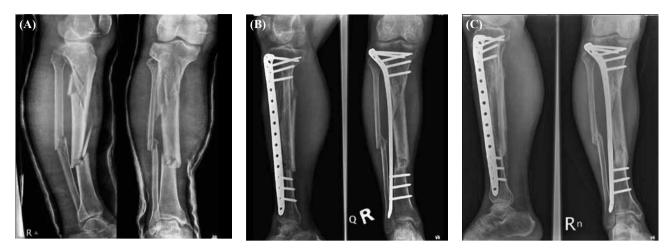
A 48 years old male, suffered from a road traffic accident, had intra-articular and multi-fragmentary fractures of his right tibia. Initially, closed reduction with long leg cast was managed but loss of alignment at follow-up x-rays film (A). In 8 days after the injury, closed plating was done (B). Eight months after the operation, there was bony union (C).
